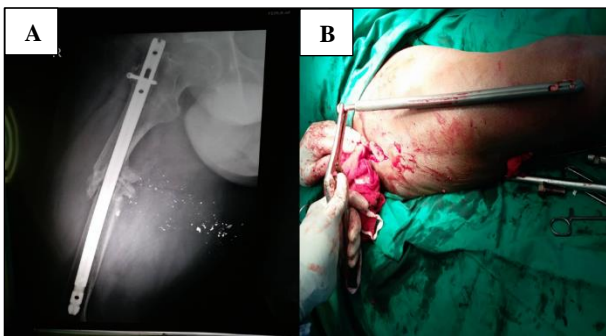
Plain radiograph of nonunited femoral fracture from gunshot injury with intramedullary nail in situ (3A). Removed intramedullary nail with bolt in situ (3B).
